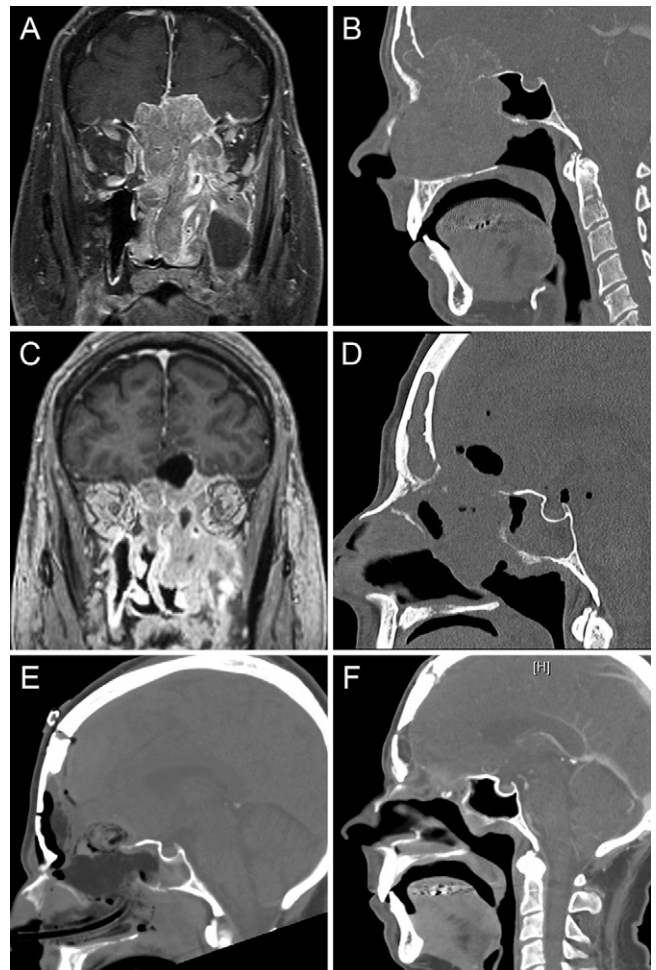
Preoperative coronal contrast-enhanced T1-weighted MRI (A) and sagittal CT (B) revealed a soft tissue mass centered within the ethmoid and left maxillary sinuses with extension into the pterygopalatine fossa, foramen rotundum, ethmoid roof, and cribriform plate to the frontal lobe. Two months after initiation of sorafenib, MRI (C) and CT (D) revealed a significant reduction in tumor burden, causing extensive skull base defects and consequent pneumocephalus. A craniofacial approach was pursued for tumor resection and anterior skull base repair with durable results on CT immediately postoperatively (E) and at 34 months' follow-up (F).
